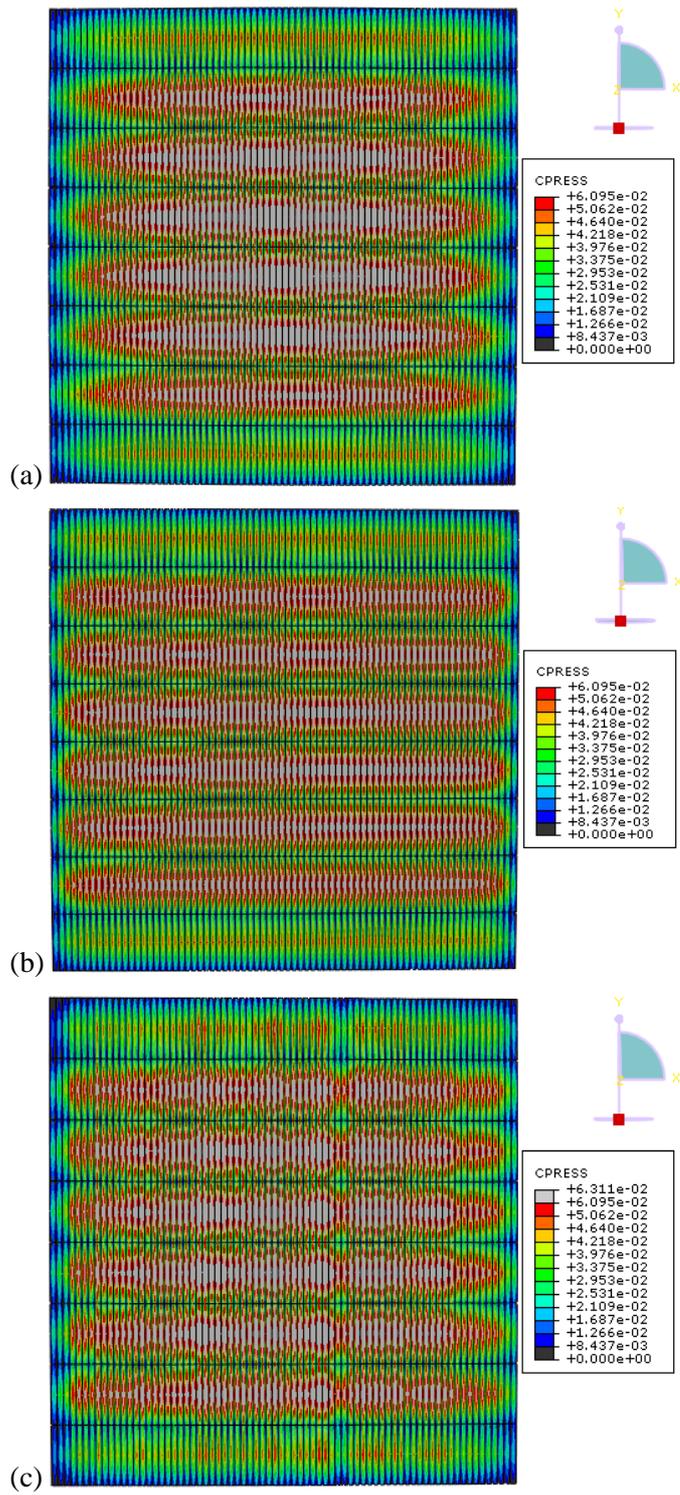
Contour of contact pressure (MPa) on the cartilage surface of (a) the Isotropic-3D, (b) the Uniform-3D and (c) the DT-MRI-3D model at the end of ramp loading ($t = 2s$).
